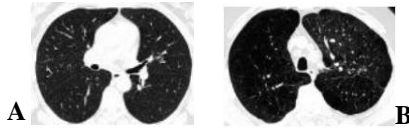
Visual appearance of lung tissue on an axial CT for a normal patient (A) and an emphysema patient (B)
